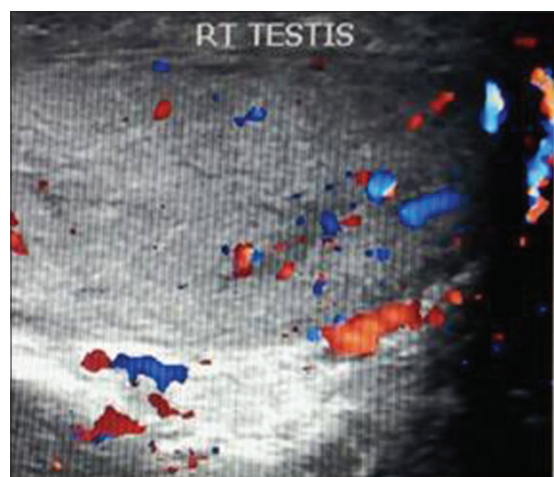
Color Doppler ultrasound image
